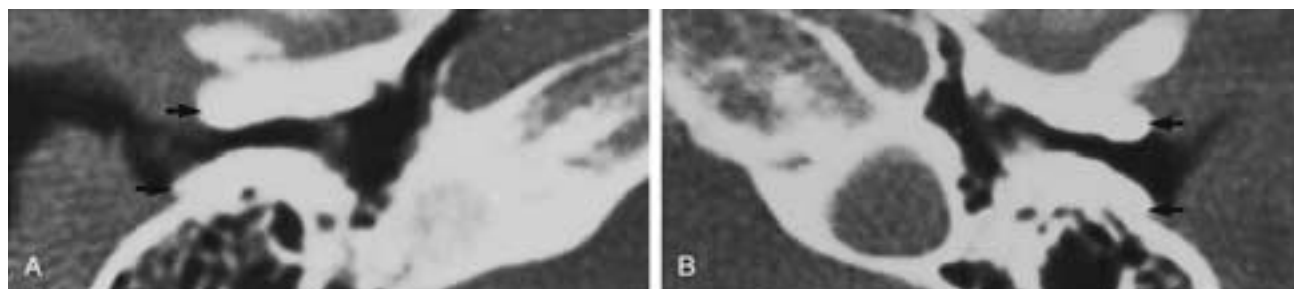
Bilateral EAC exostoses. A and B, CT. Sclerotic bone (arrows) layered on the anterior and posterior walls of the tympanic bone has diffusely narrowed EACs. (Compare with Fig. 25-112; courtesy of Dr. Anton N. Hasso.)
